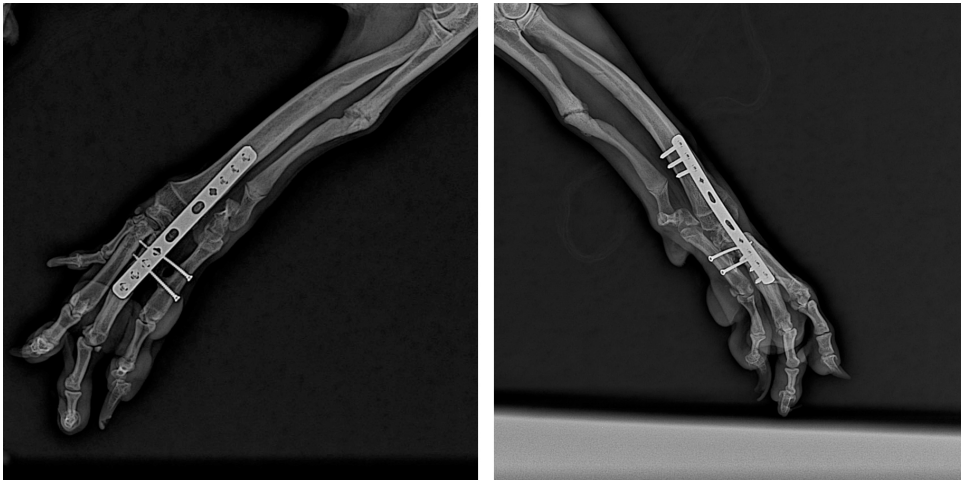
A / P and M / L radiography taken at the third month postoperative control.
